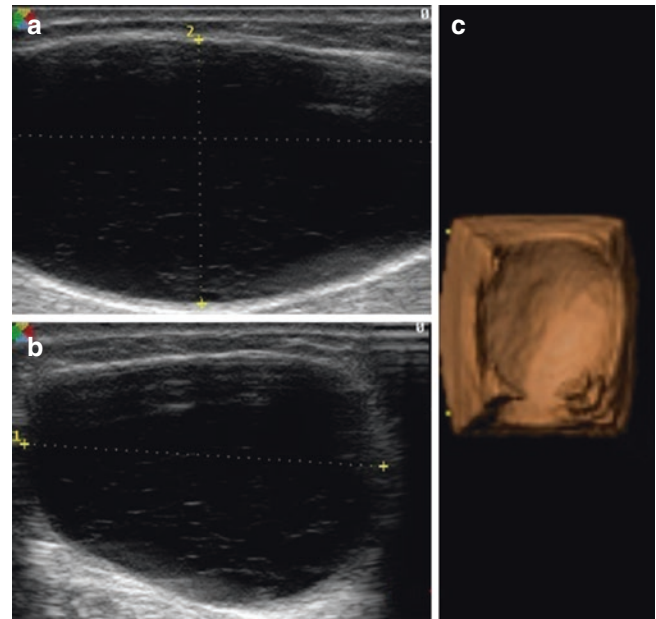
Groin lymphocele. Ultrasound image of a groin lymphocele diagnosed in a 6-year-old boy (22 kg) who presented for a non-pulsatile painful groin mass 1 week after right femoral artery catheterization. Grayscale image in long (a) and short (b) axis views of a 2 × 5 cm anechoic cystic collection. The lymphocele in a 3D reconstructed image (c)
